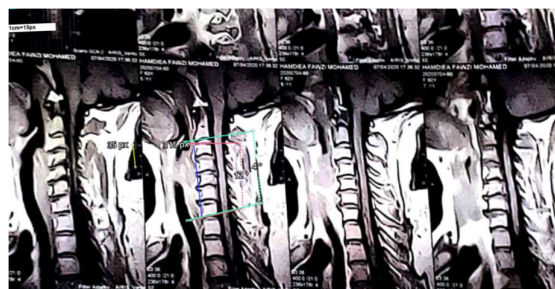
Case 1 Preoperative T1 MRI sagittal view of cervical vertebrae.
